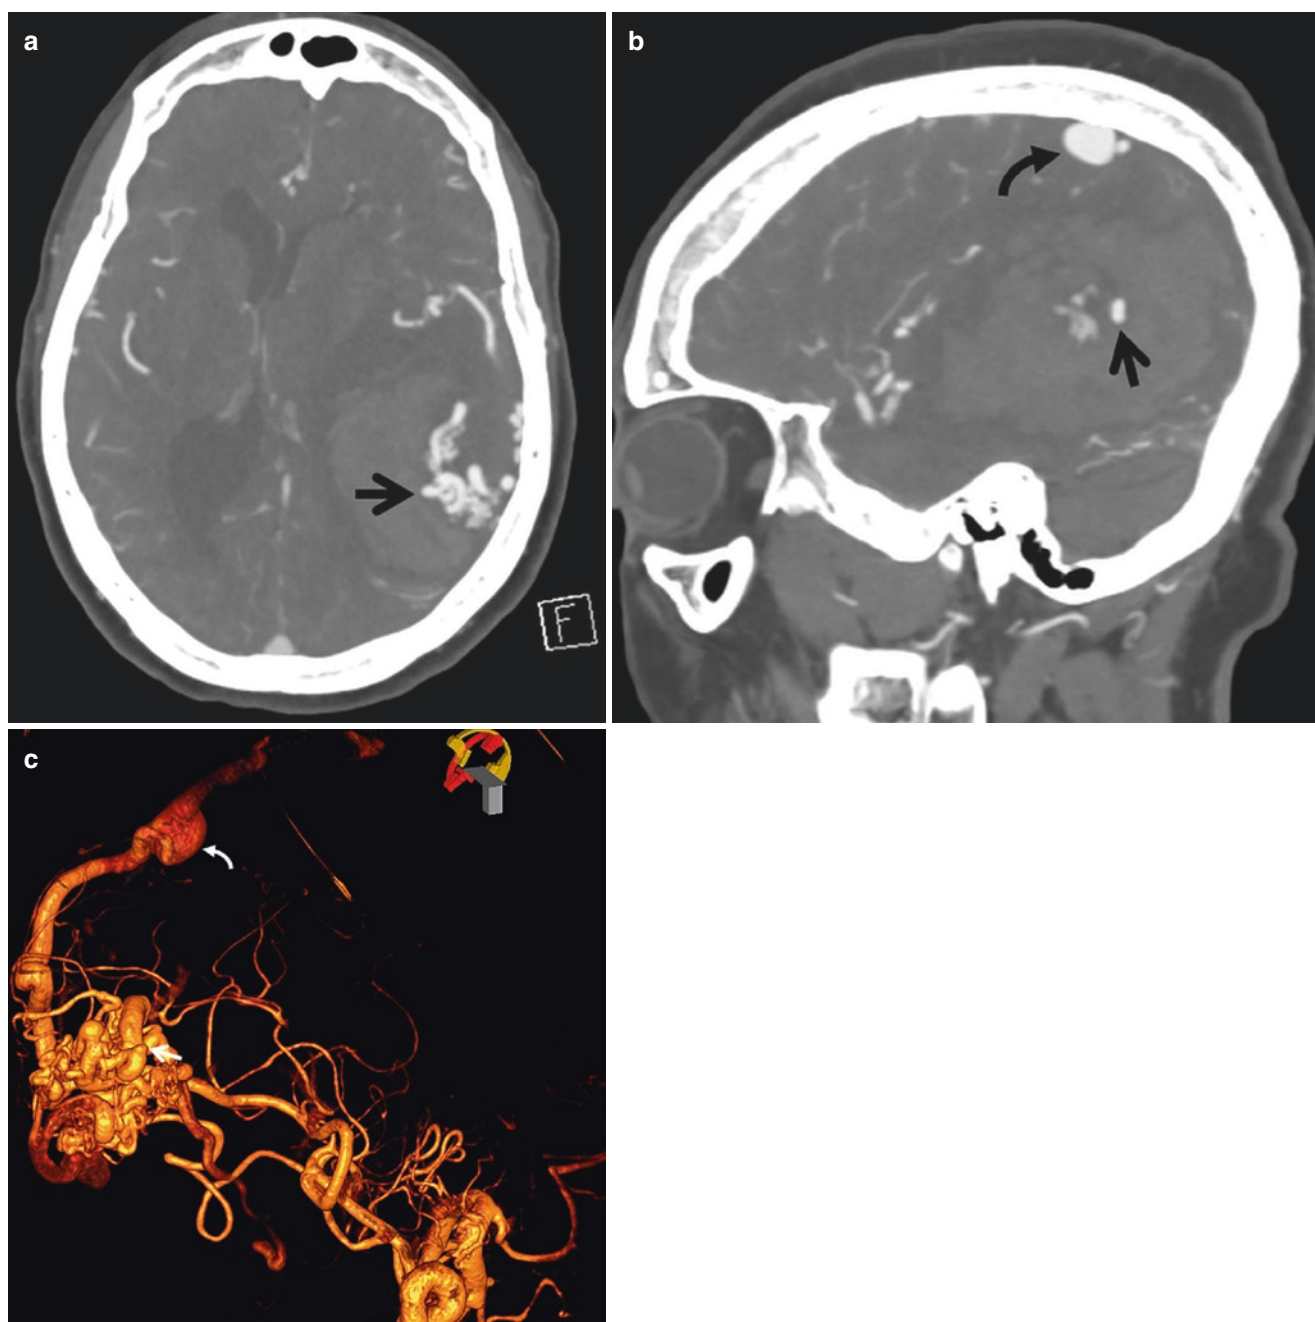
Ruptured AVM. Patient with left intracerebral hemorrhage. (a) CTA axial image shows a ruptured AVM with an intranidal aneurysm (*arrow*). (b) Sagittal MIP again demonstrates an intranidal aneurysm as the source of hemorrhage. Note a venous pouch superiorly adjacent to the superior sagittal sinus (*curved arrow*). (c) 3D rotational
